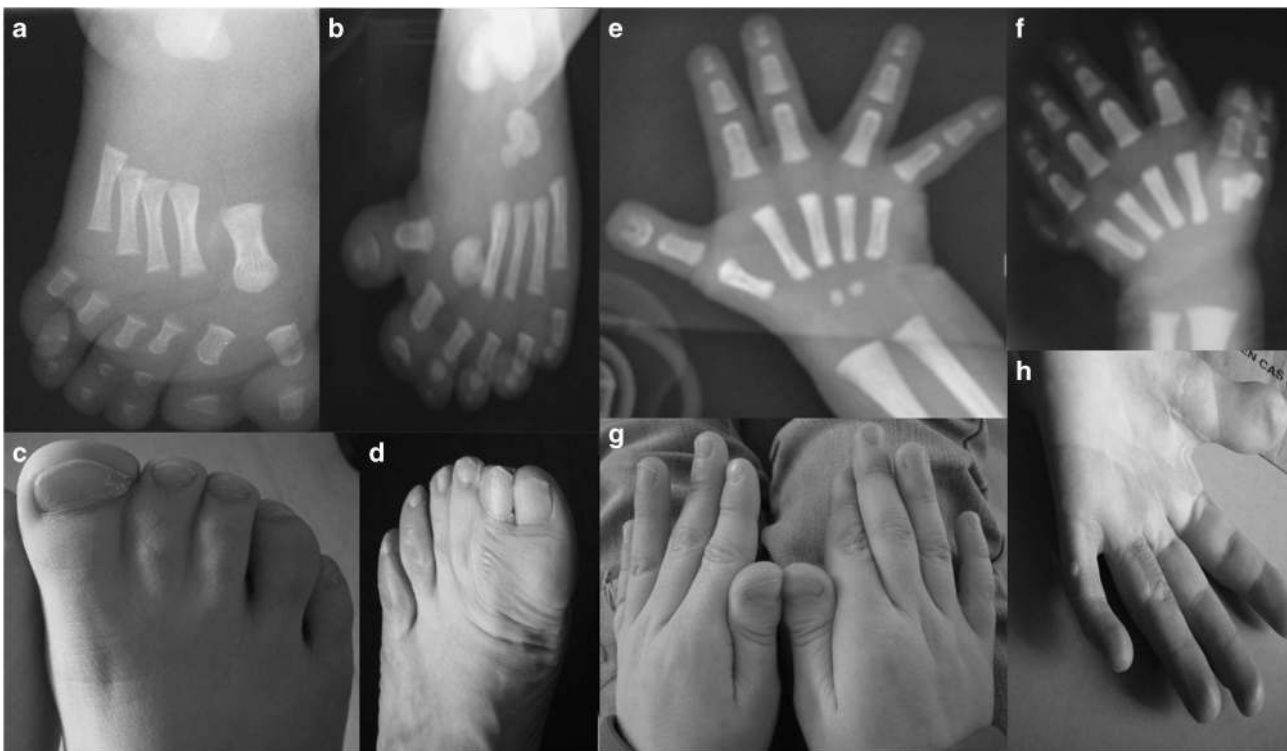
Photographs and radiographies of GCPS cases with identified *GLI3* mutation. (a, b) Preaxial polysyndactyly in the feet with a broad first metacarpal on X-rays (G076, G14083). (c) Broad hallux and syndactyly (G16012, daughter). (d) Preaxial polysyndactyly (G16012). (e) Bifid terminal phalanx of the thumb (G14083). (f) Heptadactyly (preaxial and postaxial PD, G15198). (g) Broad thumbs (G16012, daughter). (h) Broad thumb and postaxial PD type (b) (G16012).
